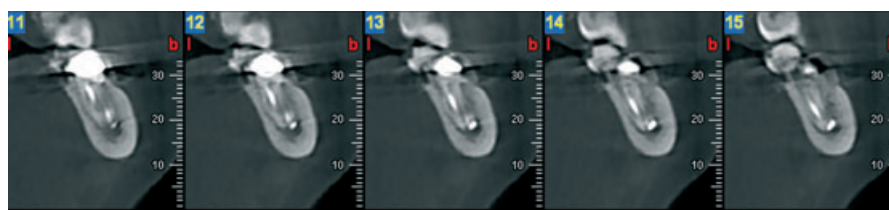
CBCT examination (coronal slices/cuts) of tooth 37 revealing filling material extruded in the mandibular canal.
